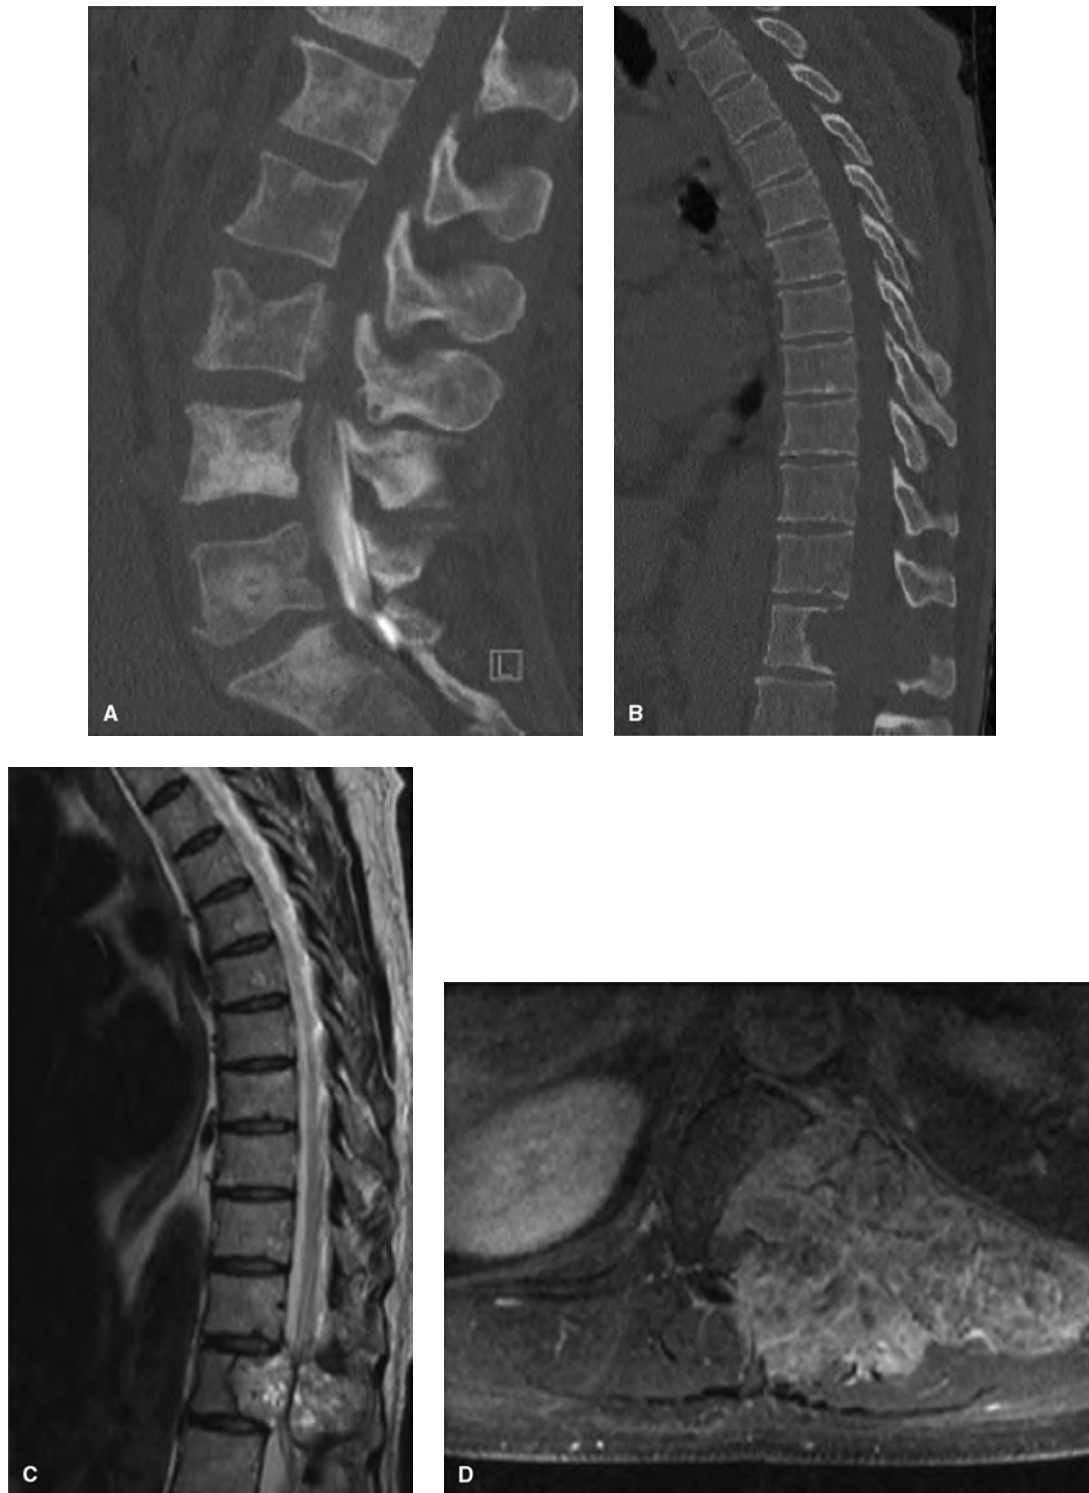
(A) Sagittal postmyelogram CT demonstrating a complete block due to epidural compression from a breast metastasis. The block, located at the L3/4 disc space demonstrates the lower extent of the mass. This was predominantly an epidural mass which occurs in a small minority of cases. (B) Sagittal CT scan demonstrating lytic destruction of the T12 vertebral body due to a breast metastasis. Despite the extensive destruction there is no collapse of the vertebral body or kyphosis of the spinal canal. Destruction of the posterior elements is also seen. (C) T2-weighted sagittal MRI demonstrating the T12 breast metastasis and the severe spinal cord compression. The spinal fluid appears white on this sequence. The tapering of the spinal fluid on the sagittal image in the region of the mass is characteristic of compression from an extradural mass. (D) T2-weighted axial MRI demonstrating the T12 breast metastasis and the severe spinal cord compression. The axial image demonstrates significant paraspinous extension as well.
